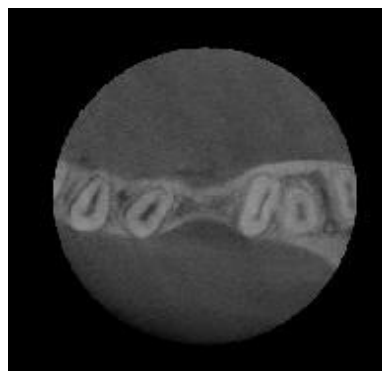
CBCT indicated width of edentulous ridge was less than width of mesial root of the mandibular second molar
